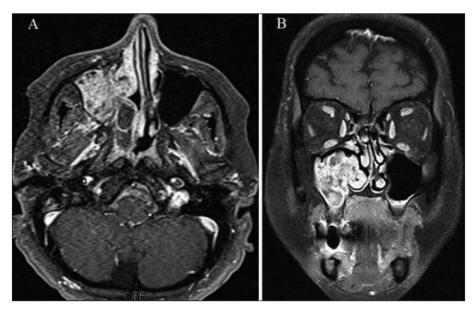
Magnetic resonance Imaging of the paranasal sinuses in the axial T1-weighted plane shows a well-circumscribed hypointense mass with non-homogenous, intensive contrast enhancement (A) and a non-homogenous hyperintense signal intensity on T2-weighted coronal image (B).
